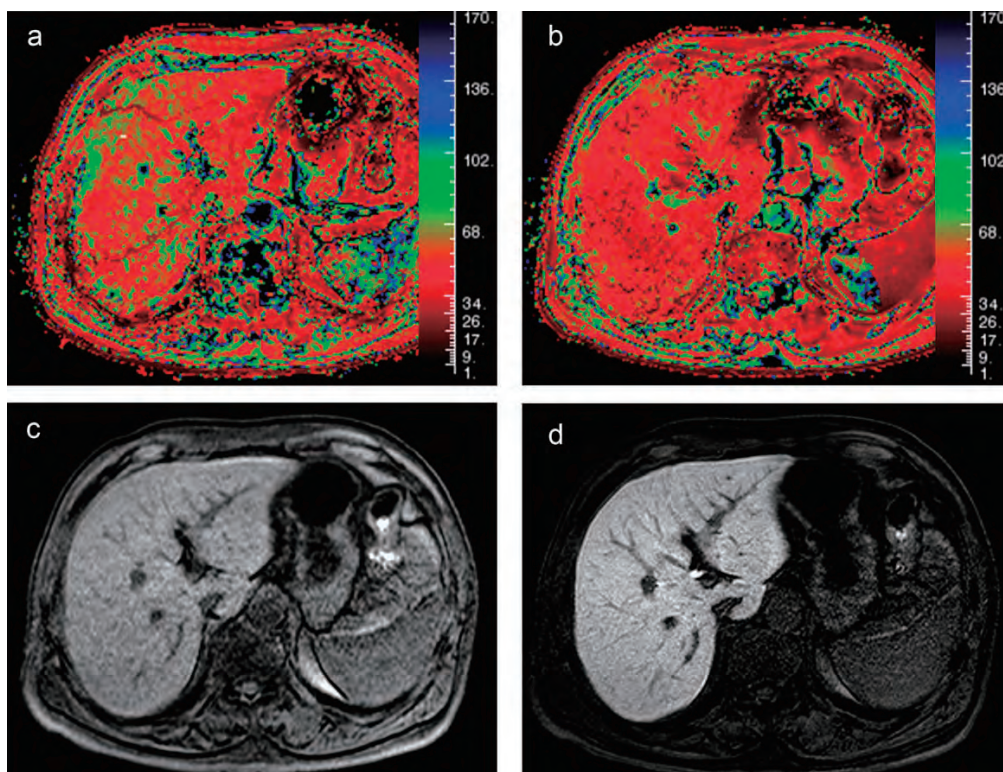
Normal liver function in a 67-year-old man. Mean T2* values of the liver on pre- and post-contrast at 18 min were 49.7 ms and 39.8 ms, respectively. The reduction rate of T2* value was 19.9%. T2* value mapping of the liver on post-contrast T2* value mapping (b) showed darker red than that on pre-contrast mapping (a). This means that the T2* shortening effect after Gd-EOB-DTPA administration shows as darkening of liver parenchyma on T2* value mapping. On fat-suppressed T1-weighted GRE imaging (TR/TE, 2.13/4.31; flip angle, 15°) of pre- (c) and post-contrast (d) at 20 min, liver-to-muscle signal intensity ratios were 1.63 and 2.73, respectively. The increase rate was 1.67. We also noticed that the window level and width differed on each image (c, d) when paying attention to signal intensity differences in erector spine muscle.
